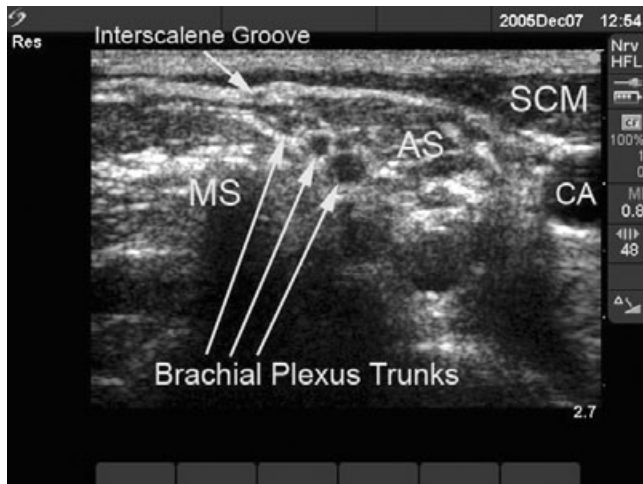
Ultrasound view for performing an interscalene nerve block. Note the round appearing nerves in the interscalene groove that have a hypoechoic interior surrounded by a hyperechoic exterior appearance. They are located between the anterior scalene (AS) and middle scalene (MS) muscles. The carotid artery (CA) that pulsates during real-time visualization is a helpful anatomic landmark. The sternocleidomastoid muscle (SCM) is noted. If the patient is asked to Valsalva, the internal jugular vein usually can be visualized.
